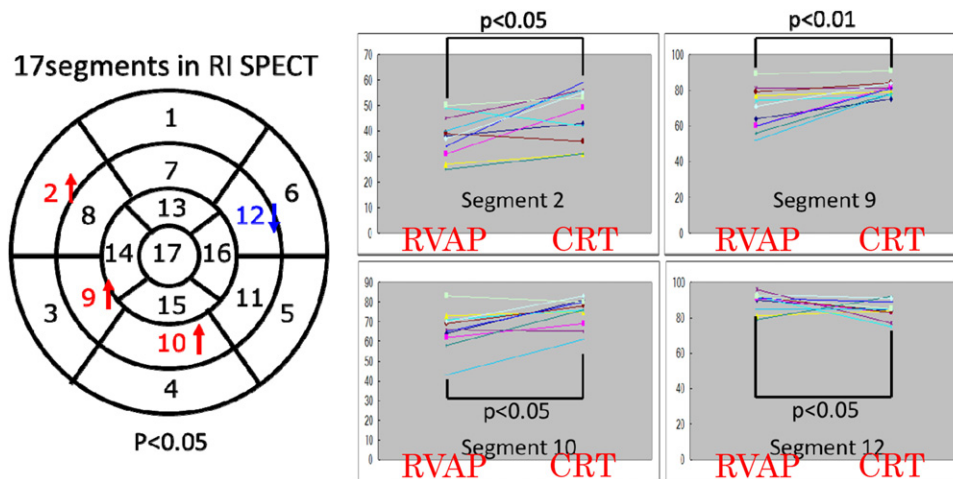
Changes in %uptake of blood perfusion of 17 LV segments by RI SPECT before and after upgrading to CRT. The %uptake of blood perfusion increased at the inferoseptal region (segment 9 and 10), and decreased at the contrary lateral region (segment 12).
